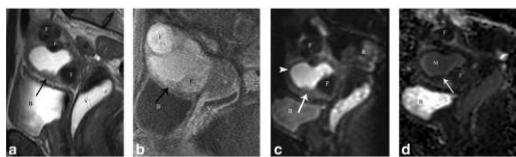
A 59-year-old woman with vaginal spotting and Grade II endometrial cancer. Sagittal T2WI (a), 3D T1-weighted DCE MRI (b), and FOCUS (d) show fibroids (F) and the tumor (arrow) in the anterior lower uterus, with superficial myometrial invasion, difficult to see on DCE MRI (b) owing to blood products in the endometrial cavity. The tumor is isointense to the myometrium on DCE and is better seen on FOCUS and T2WI (d). The apparent diffusion coefficient map, with M representing blood products. B: bladder; V: vagina with gel; R: rectum.
